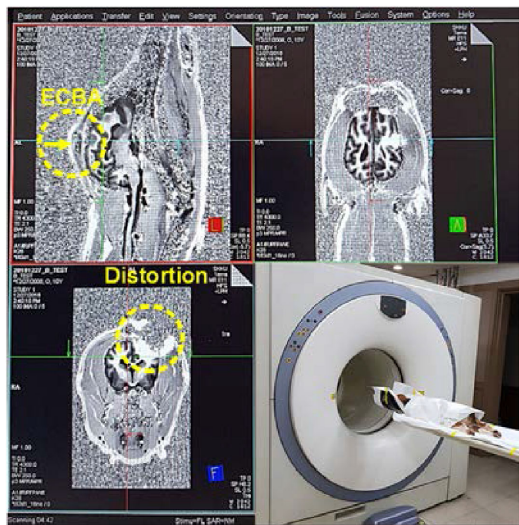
MRI images after implantation of ECBA module (#0, pilot subject, sliced plane).
